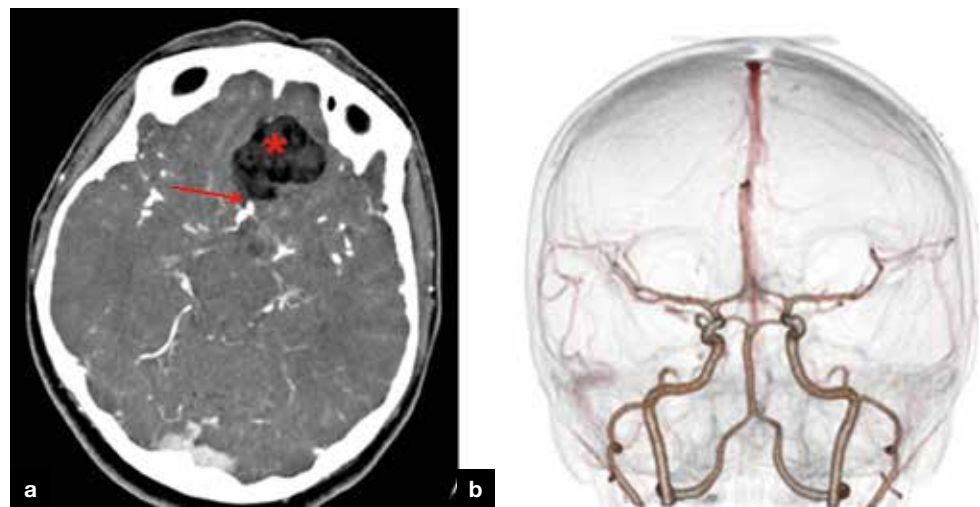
a. Computed tomography scan revealed a low-density lesion in the anterior cranial fossa. The lesion is close relationship with the anterior communicating artery (arrow). b. Computed tomography angiography showed normal cerebral arterial anatomy.
